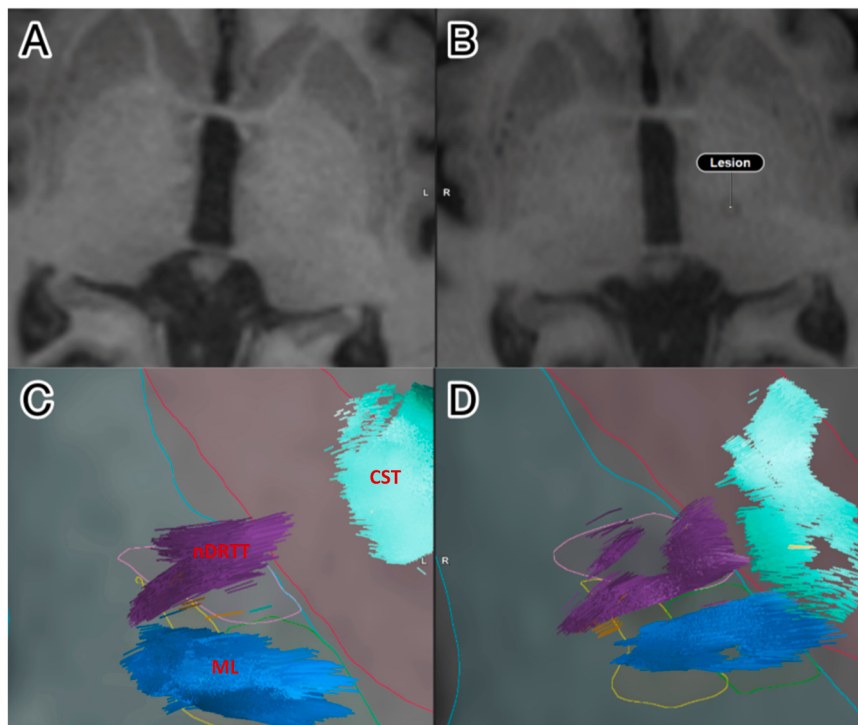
Axial T1-weighted images of lesion sites in a 62-year-old right-handed male with TDPD. (A) Pre-op. (B) Immediate post-op ablation site. Lesion core and surrounding edema is observed. (C) FT2 tractography overlay with superimposed stereotactic atlas pre-op. The nDRTT (purple), medial lemniscus (blue), and corticospinal tract (green) are shown. The xDRTT could not be successfully tracked. Atlas registration shows the internal capsule (red outline), thalamus (blue outline), and VIM (pink outline), VPL (green outline), and ventral posteromedial nucleus (VPM; yellow outline). (D) FT2 tractography overlay with superimposed stereotactic atlas immediately post-op. The nDRTT (purple), medial lemniscus (blue), and corticospinal tract (green) are shown. The xDRTT could not be successfully tracked. Atlas registration shows the internal capsule (red outline), thalamus (blue outline), and VIM (pink outline), VPL (green outline), and VPM (yellow outline). Abbreviations for key structures are displayed on the images in bold red text for clarity.
